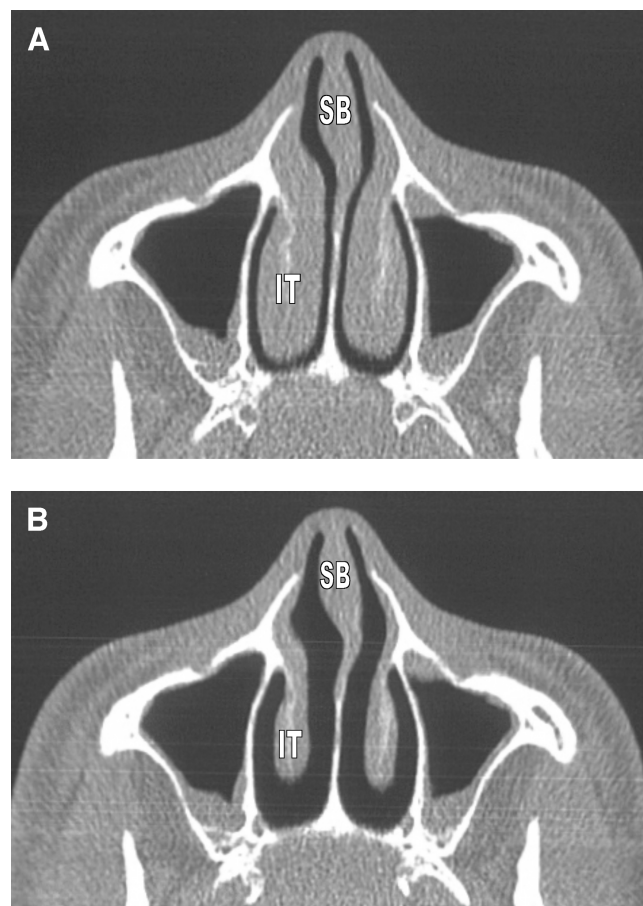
Modified axial CT reconstruction, angled up 30° anteriorly to show the nasal swell body (SB) and inferior turbinates (IT) in the same section. The SB straddles the piriform aperture at this level. (A) Undecongested nose showing thin relatively uniform air passages. (B) Decongested nose showing marked widening of the air passages; the SB is less vasoreactive than the IT in this section. The bulge of the inferior turbinate anterior head is located a few millimeters more posteriorly in the decongested state.
